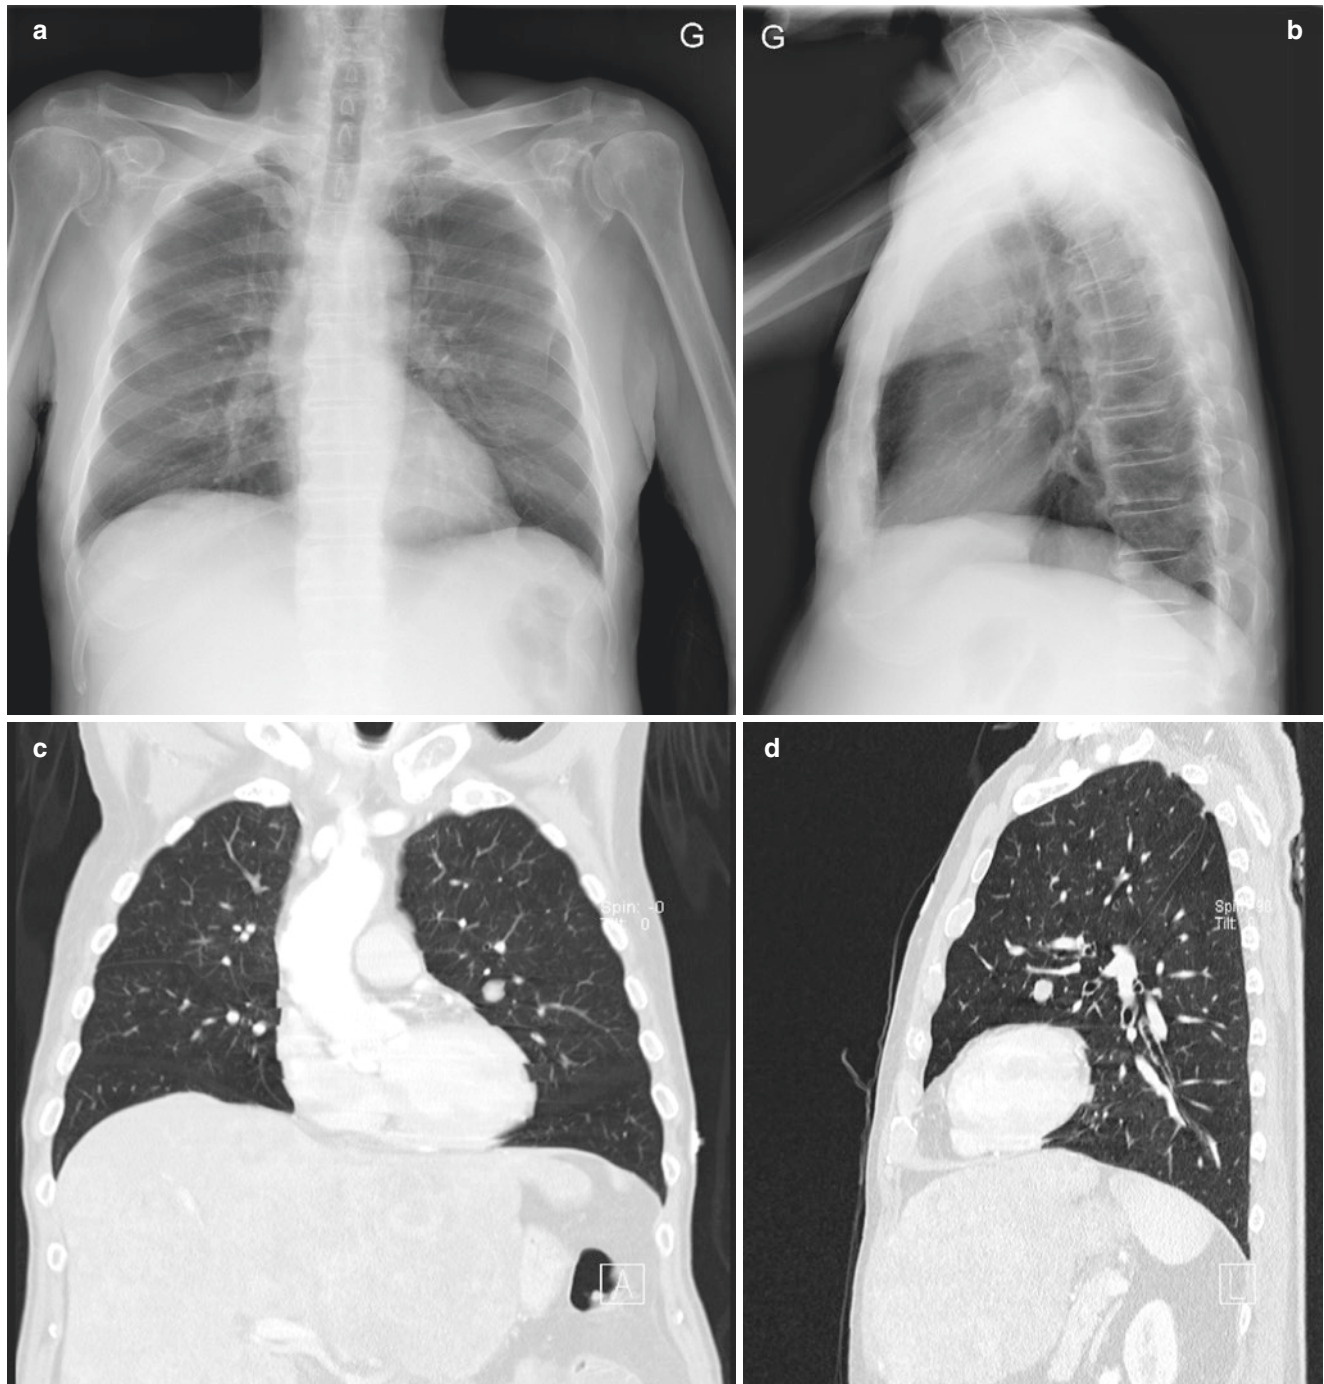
A 77-year-old man with right upper quadrant pain. Postero-anterior (a) and lateral (b) radiographs interpreted as normal. With hindsight, the 13 mm nodule in the superior segment of the lingula can
